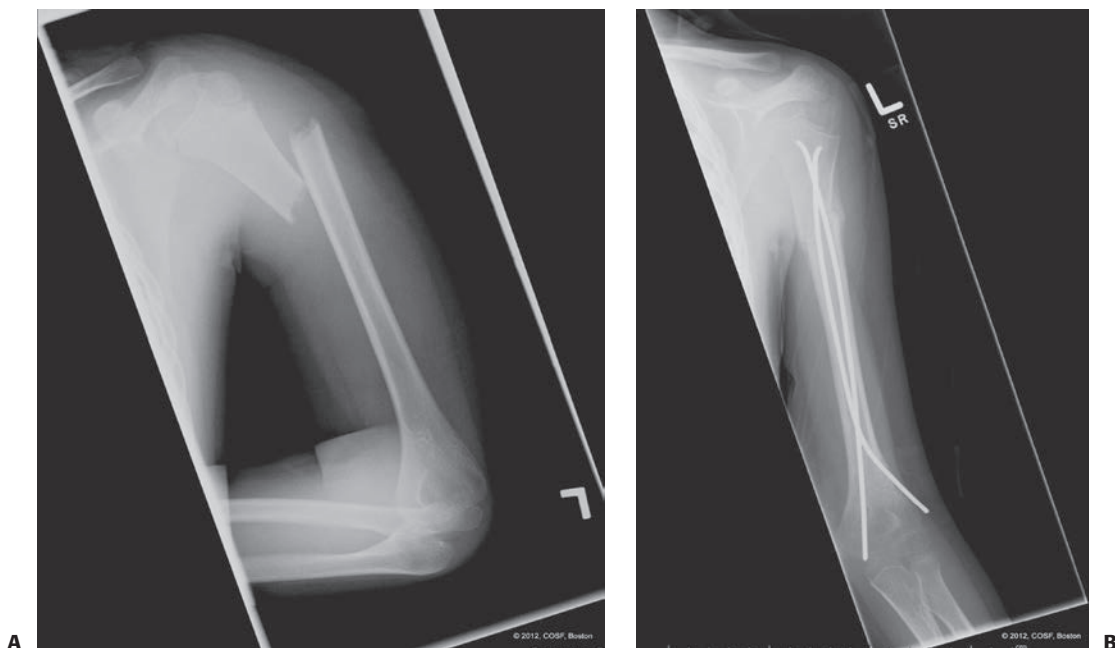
Intramedullary fixation of a proximal humeral metaphyseal fracture. A: Preoperative radiograph depicting displacement and shortening. B: Postoperative radiographs depict bony healing.
